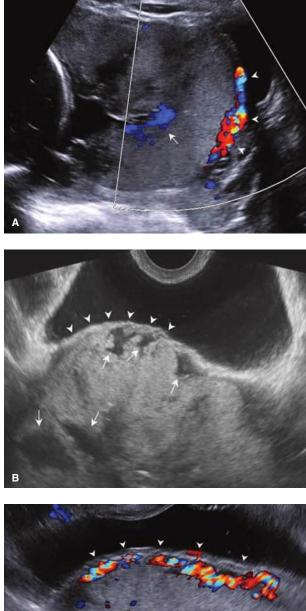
These third-trimester sonograms demonstrate findings that characterize placenta accreta spectrum. A. Transabdominal color mapping depicts bridging vessels between the bladder and the uterine serosa (*arrowheads*) and shows large intraplacental lacunae (*arrow*). B. Transvaginal transverse image showing a large bulge (suggesting placenta percreta) along the bladder-uterine serosal interface (*arrowheads*) and multiple large, irregular lacunae (*arrows*). C. Disruption of the bladder-serosal interface. The echogenic interface between bladder and serosa appears irregular (*arrowheads*). The smallest myometrial thickness measures <1 mm, and bridging vessels are highlighted by color Doppler. Large lacunae also are shown (*arrows*).
